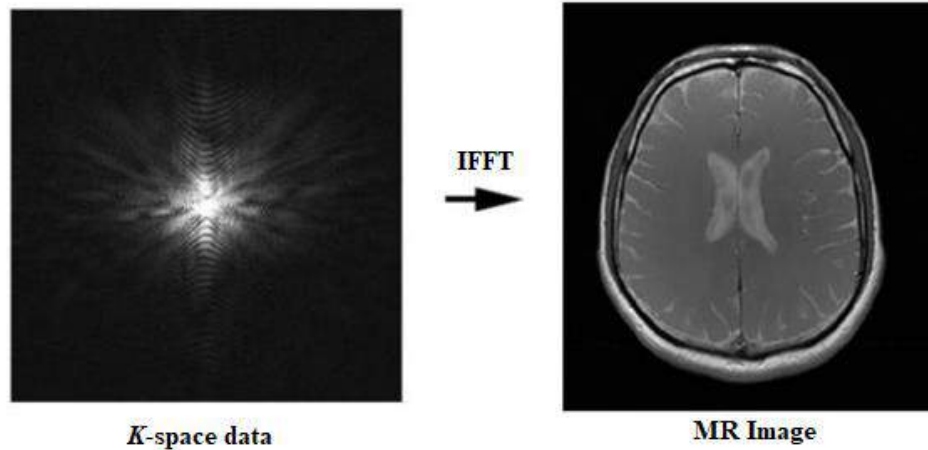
$k$ -space and MR image
